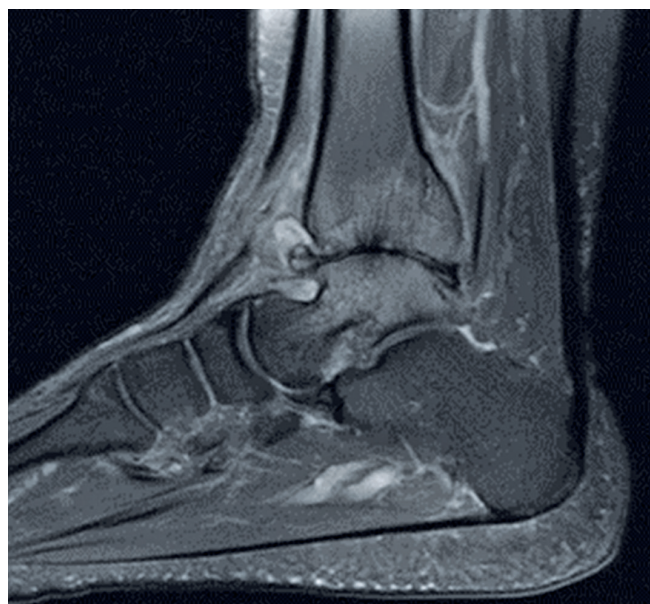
T2-weighted resonance image with signs of bone edema in the tibiotalar joint and degenerative joint clamping. Examination of August 2022.
